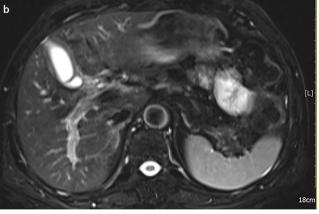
a, b. Abdominal MRI+MRCP: a) MRCP shows the extent of reduction of the extrahepatic bile duct stenosis (red arrow), with dry branch-like changes in the intrahepatic bile duct with uneven thickness; the thickness of the main pancreatic duct also shows uneven changes. b) The results of T2 WI fat saturation sequencing show thinning of the gallbladder and common bile duct wall, a reduced extent of bile duct stenosis, and slightly reduced lymph nodes behind the common bile duct.
